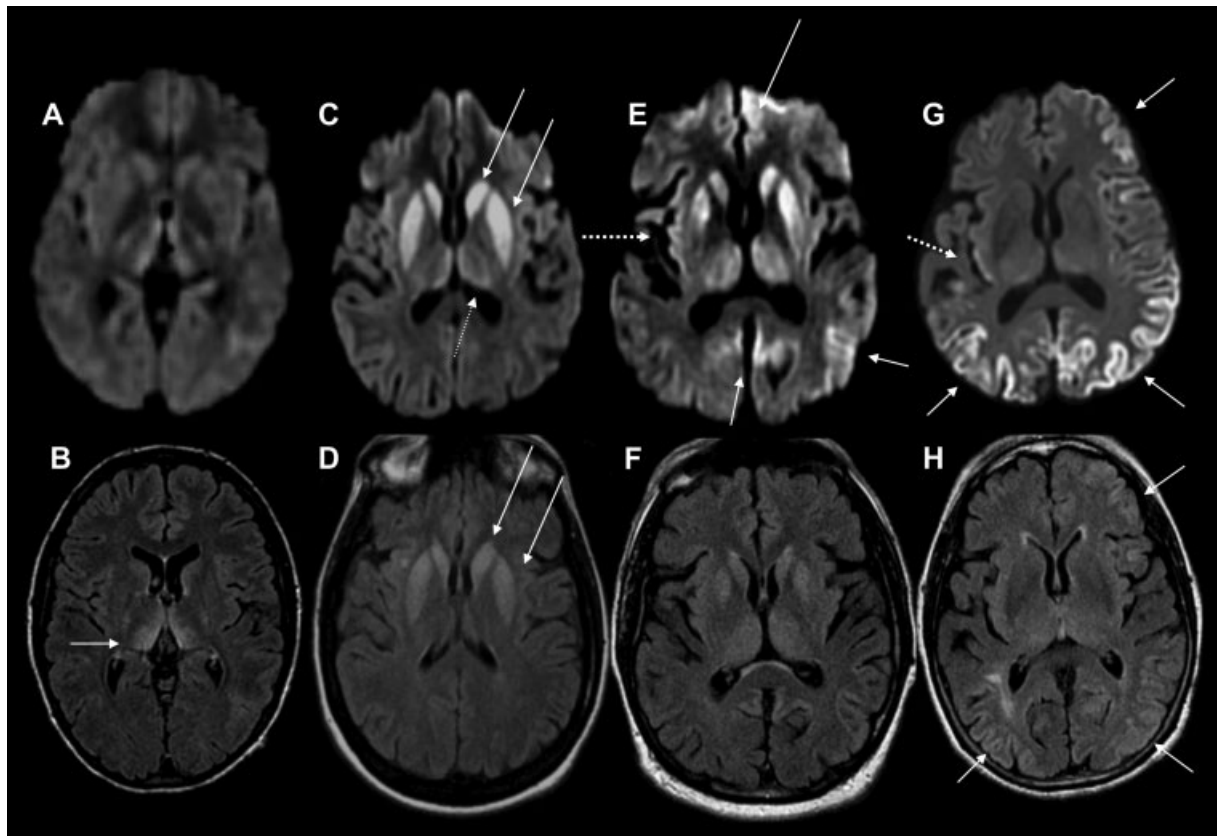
Magnetic resonance imaging (MRI) findings in pathologically proven Jakob–Creutzfeldt disease (JCD). Note that in sporadic JCD the abnormalities are usually more evident on diffusion-weighted imaging (DWI) (C,E,G) than on fluid-attenuated inversion recovery (FLAIR) images (D,F,H). Orientation is radiologic, with right side of image being left side of the brain. (A,B) A 21-year-old woman with probable variant JCD. MRI shows the “double hockey stick sign”: bilateral thalamic hyperintensity in the mesial pars (mainly dorsomedian nucleus) and posterior pars (pulvinar) of the thalamus. Also note the “pulvinar sign,” with the right posterior thalamus (pulvinar) being more hyperintense than the anterior putamen on the FLAIR image (B). (C,D) A 52-year-old woman with MRI showing strong hyperintensity in bilateral striatum (solid arrows, both caudate and putamen) and slight hyperintensity in mesial and posterior thalamus (dotted arrow). (E,F) A 68-year-old man with MRI showing hyperintensity in bilateral striatum (note anteroposterior gradient in the putamen, which is commonly seen in JCD), thalamus, right insula (dotted arrow), anterior and posterior cingulate gyrus (arrow, L > R), and left temporal-parietal-occipital junction (arrow). (G,H) A 76-year-old woman with MRI showing diffuse hyperintense signal mainly in bilateral parietal and occipital cortex, right posterior insula (dashed arrow), and left inferior frontal cortex (arrow), but no significant subcortical abnormalities. Reprinted with permission from Vitali P, Migliaccio R, Agosta F, Rosen H, Geschwind M. Neuroimaging in dementia. *Semin Neurol* 2008;28(4):467–483.
